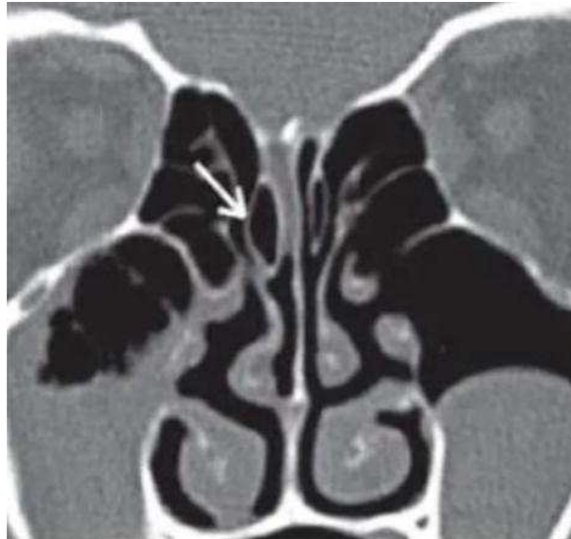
CT scan- a) Pneumatization of right middle turbinate and b) Pneumatized basal lamella
